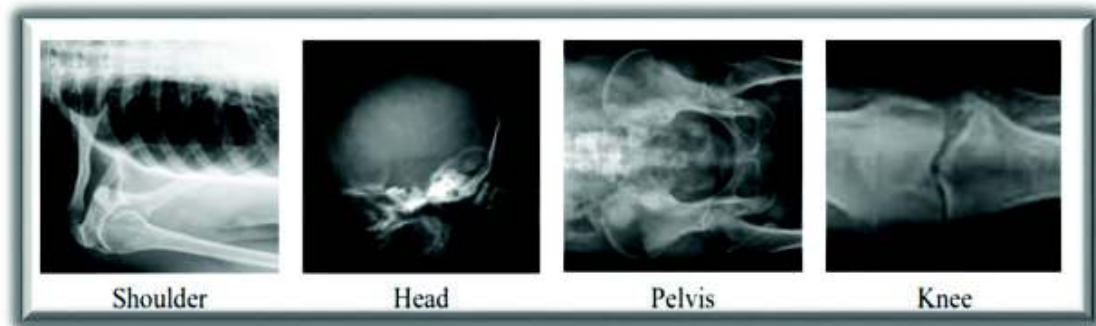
(a) Example X-ray images
